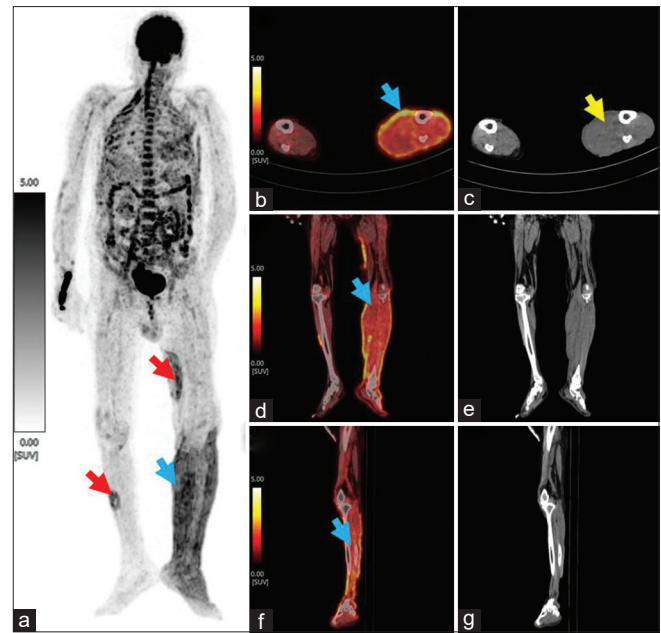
Maximum intensity projection (a) of 18-F fluorodeoxyglucose positron emission tomography-computed tomography (FDG PET/CT) scan of patient (case 3) with necrotizing fasciitis of right leg (red arrow). Images (b-g) showing fused FDG PET/CT and CT respectively, in axial (b and c), coronal (d and e), and sagittal view (f and g) of the right lower limb showing necrotizing fasciitis involving subcutaneous tissues and underlying muscles with associated edema. A focal FDG uptake is noted in the plantar aspect of the right foot
